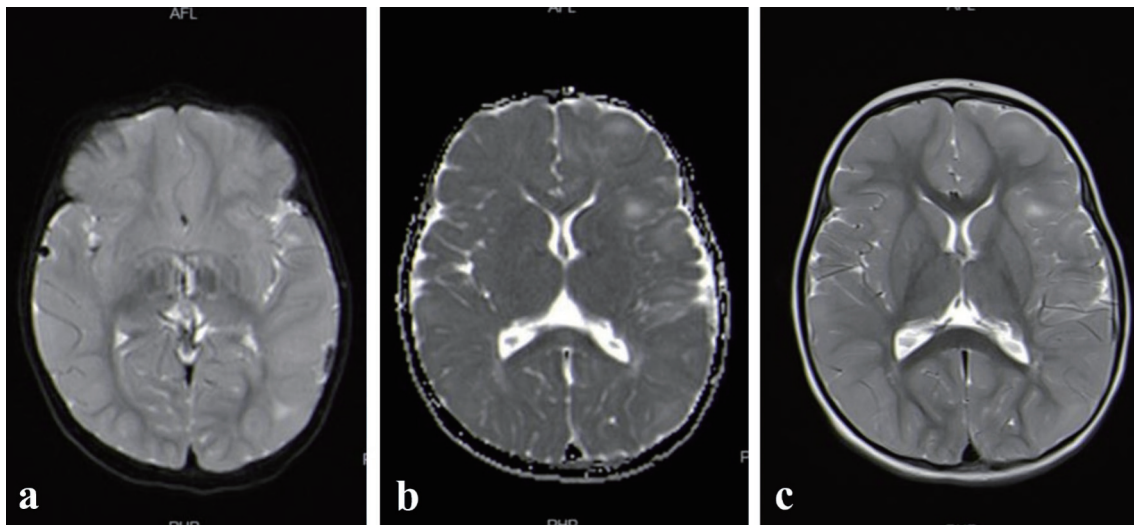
(a, b, c) Brain MRI reported multiple subependymal nodules, with a mild subtle increase in the enhancement of the lesion on the left centrum semiovale. MRI: magnetic resonance imaging.
